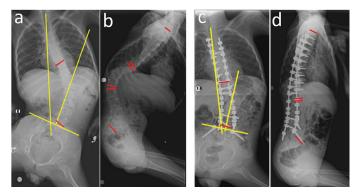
Preoperative and postoperative plain radiographs of a patient undergoing posterior spinal surgery with pelvic fixation. (a, b: Preoperative anterior posterior and lateral radiographs; c, d: Postoperative anterior posterior and lateral radiographs)
